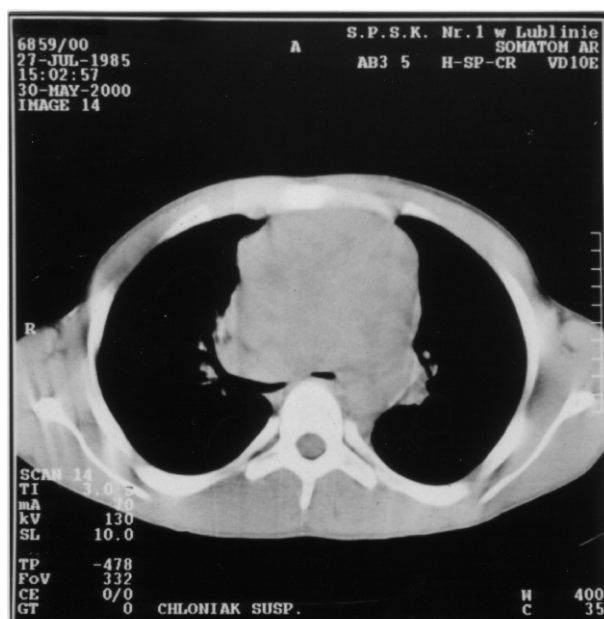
CT scans at the diagnosis with large mediastinal mass.
